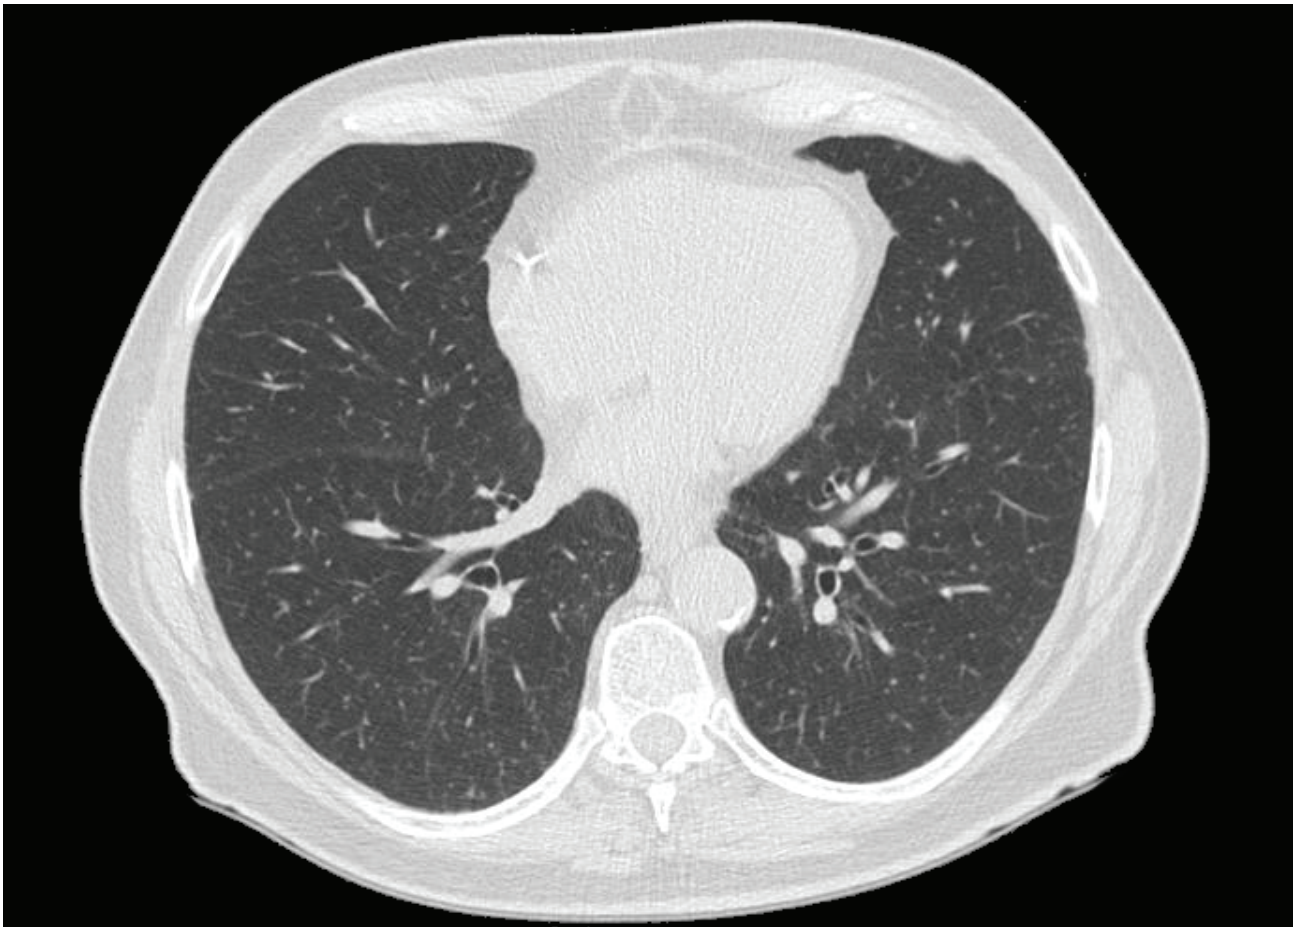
Axial image of repeat chest computed tomography scans performed 12 months after initiation of anti-tuberculosis medications: showing further improvement with resolution and calcification of many of the intrapulmonary nodules
